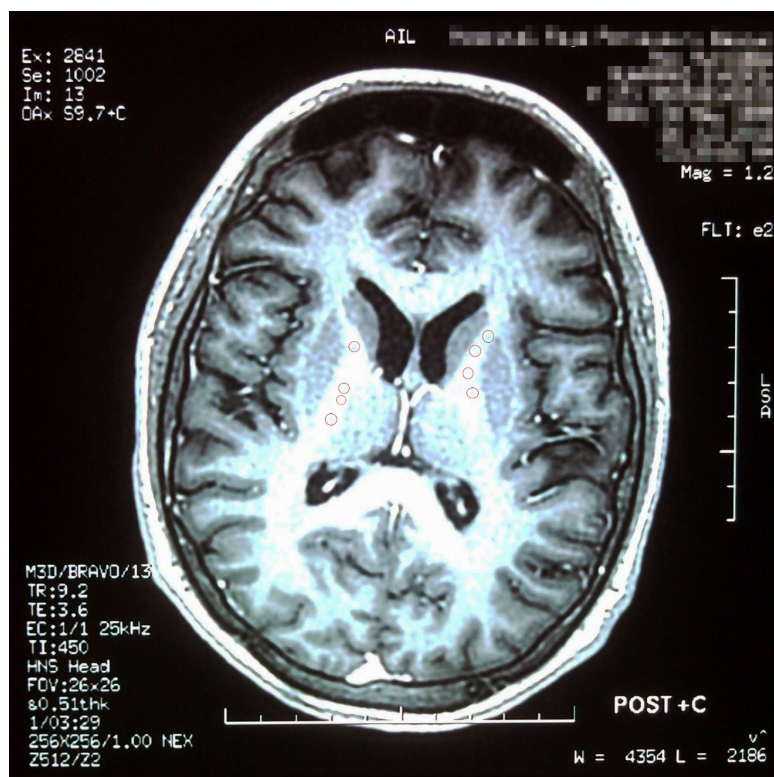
Axial T1W magnetic resonance image of the brain showing hypointense foci (red circles) in the internal capsule bilaterally. This finding is consistent with petechial haemorrhages.
